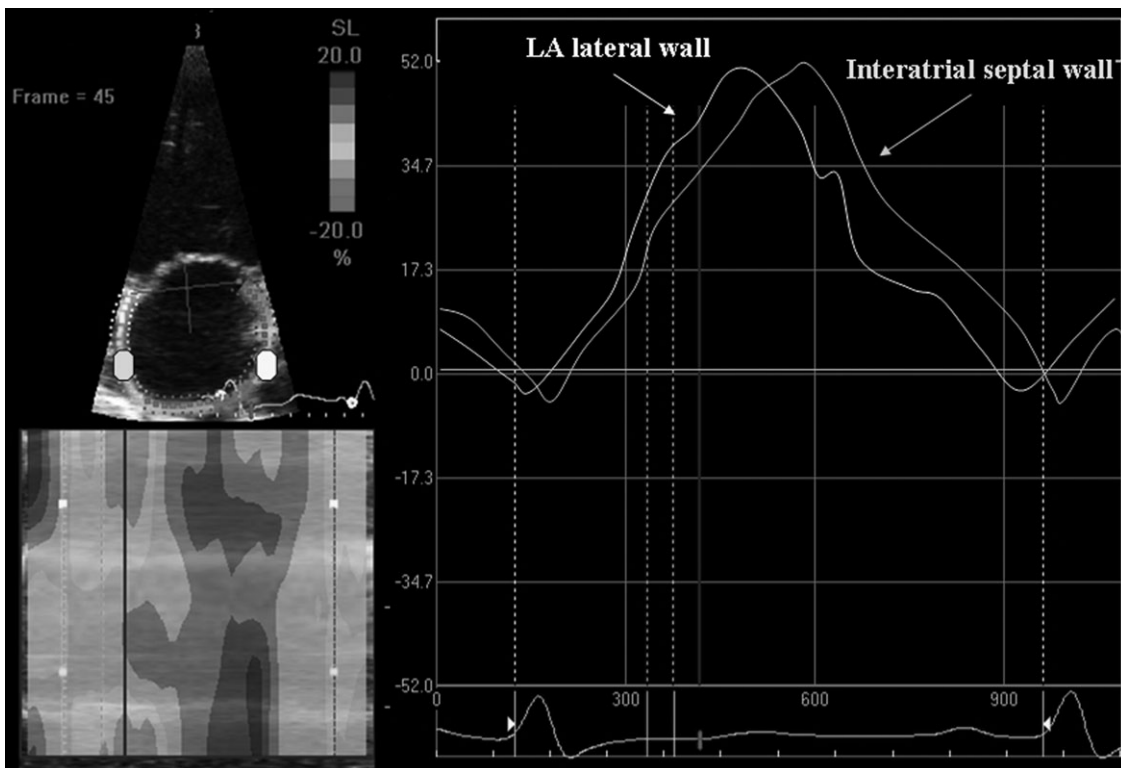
Example of longitudinal two-dimensional strain curve of basal left atrial lateral wall and basal interatrial septal wall in a control subject from an apical four-chamber view. The curve is colour coded by the defined myocardial segment as depicted in the figure (yellow, basal lateral wall; green, interatrial septal wall). Peaks of systolic strain were both >50%. See Supplementary material online for a coloured version of this figure.
